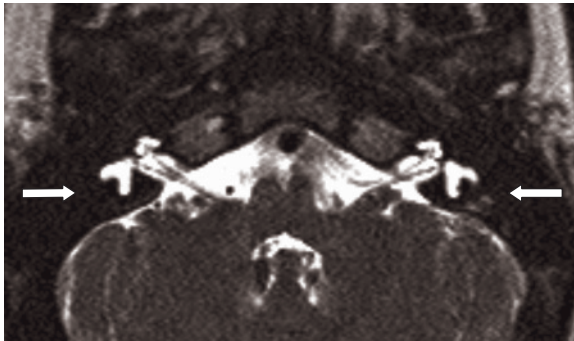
MRI scan of bilaterally dysplastic lateral semicircular canals.
